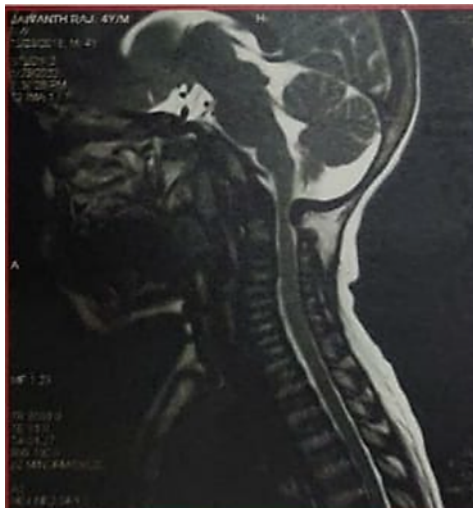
MRI Spine- Hypoplastic Dens with post dens soft tissue thickening causing canal stenosis and indenting the spinal cord at C1 level
